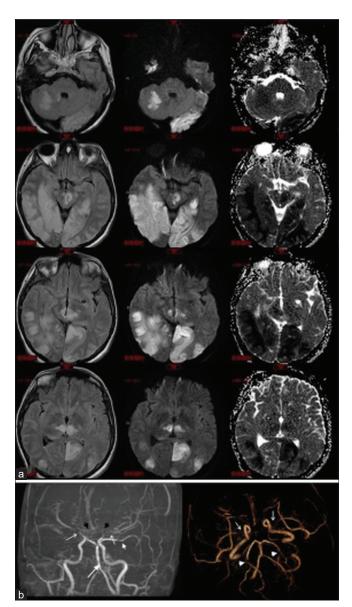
(a) MRI [(FLAIR), (DWI), (ADC) tomograms]: areas of ischemia in right cerebellum (superior cerebellar artery – SCA), mesencephalon, medial basal ganglia bilaterally (basilar artery (BA) perforators and P1 segment of posterior cerebral artery – PCA), and in occipital and basal temporal areas bilaterally (PCA). (b) MRA and volume rendering technique (VRT): bilateral occlusions of terminal ICA segments, M1 of middle cerebral artery – MCA (white arrows) and A1 of anterior cerebral artery – ACA (black arrowheads), with stenosis of BA (big white arrow) and both PCA (white arrowheads)
